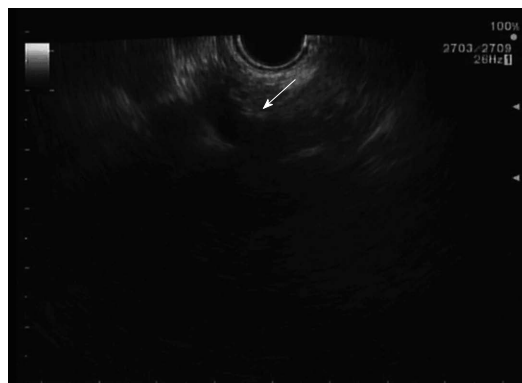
Ultrasonographic image of celiac plexus. This image is showing the celiac artery and celiac plexus (arrow).
